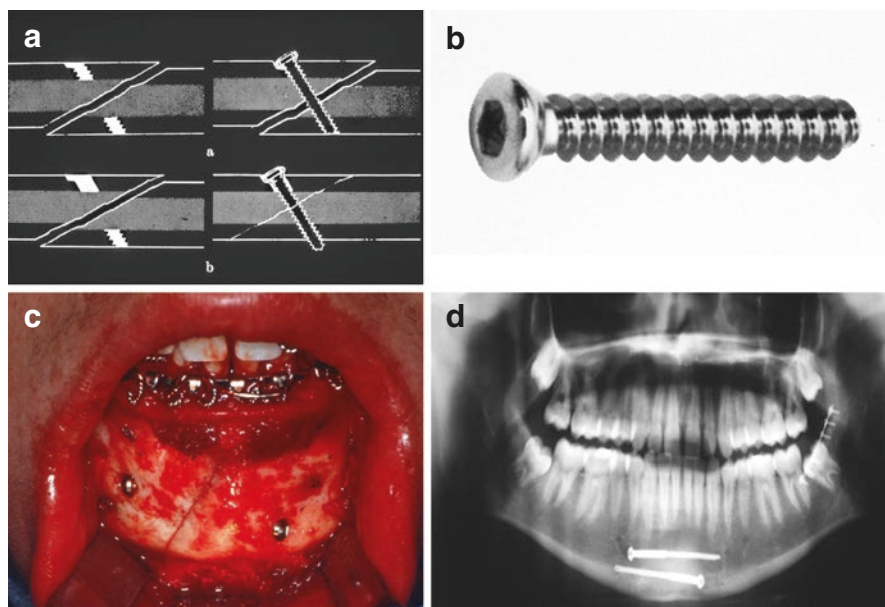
Lag screws. (a) Technique, (b) lag screw, (c) intraoperative image of lag screw application, (d) postoperative radiograph. (UT Health San Antonio)
